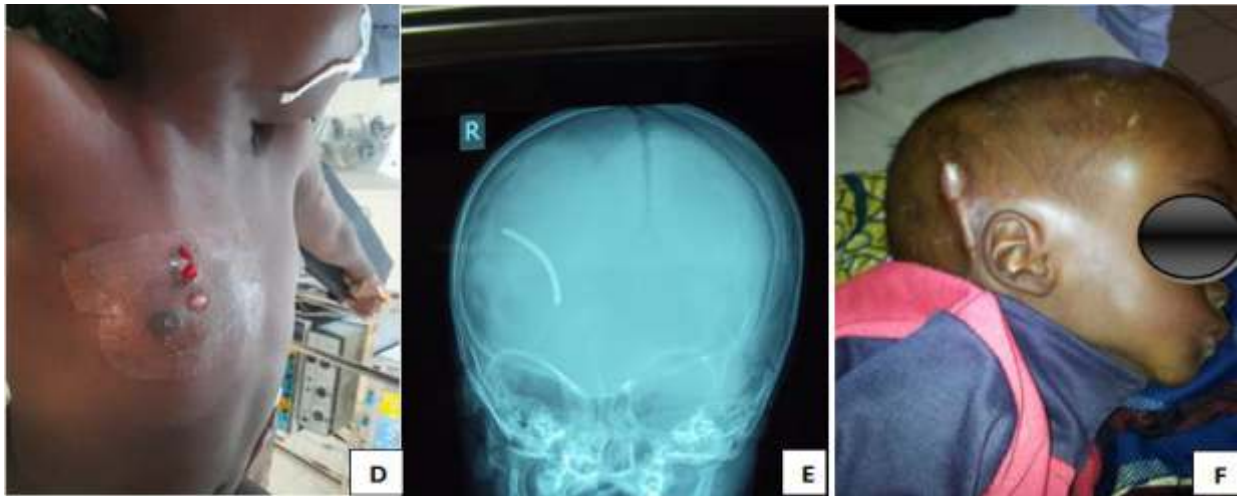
above shows a typical craniofacial disproportion in an infant with Hydrocephalus (A), an axial computed tomography (bone window) showing a calcified intraventricular catheter (B), an infant with a nodular discharging sinus along a shunt tract indicating an infection (D), a plain Anterior - Posterior skull X-ray showing total intracranial migration of a disconnected ventricular catheter (E), an infant with a near total extrusion of a Ventriculoperitoneal shunt (F).
